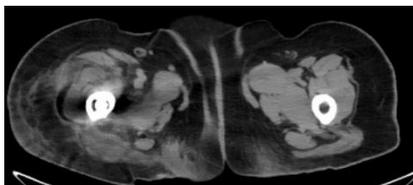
Preoperative CT scan showed multiloculated collection of thigh
